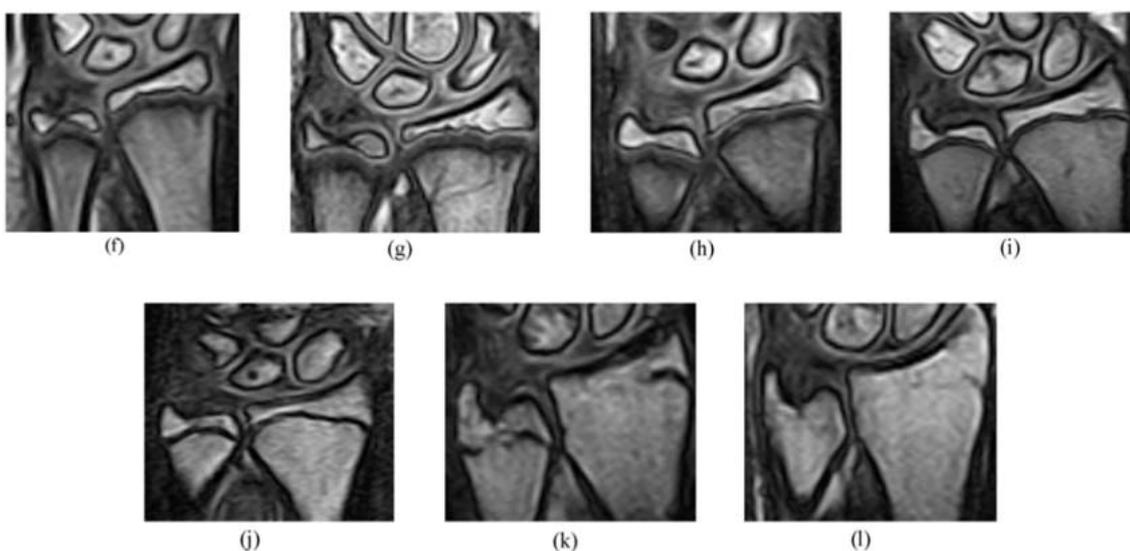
The development of the radial bone as observed in MRI-slices for the stages VI (f) to XII (l). Images from the University of Rome (Tomei et al., 2014b).
